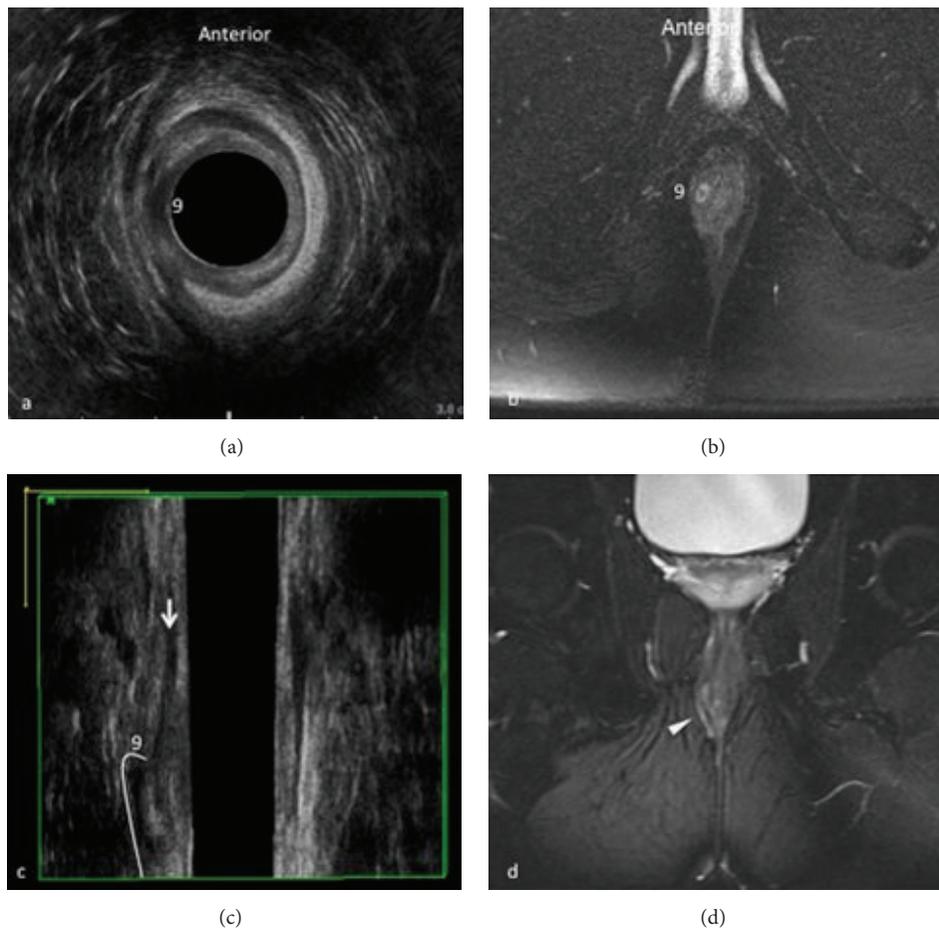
Intersphincteric fistula at 9 o'clock. 3D-EAUS demonstrates the proximal origin of the fistulous tract from the internal anal sphincter and its location in the intersphincteric plane on both axial (a) and coronal plane (c), better depicting the fistulous tract in the intersphincteric space than MRI (b, d).
